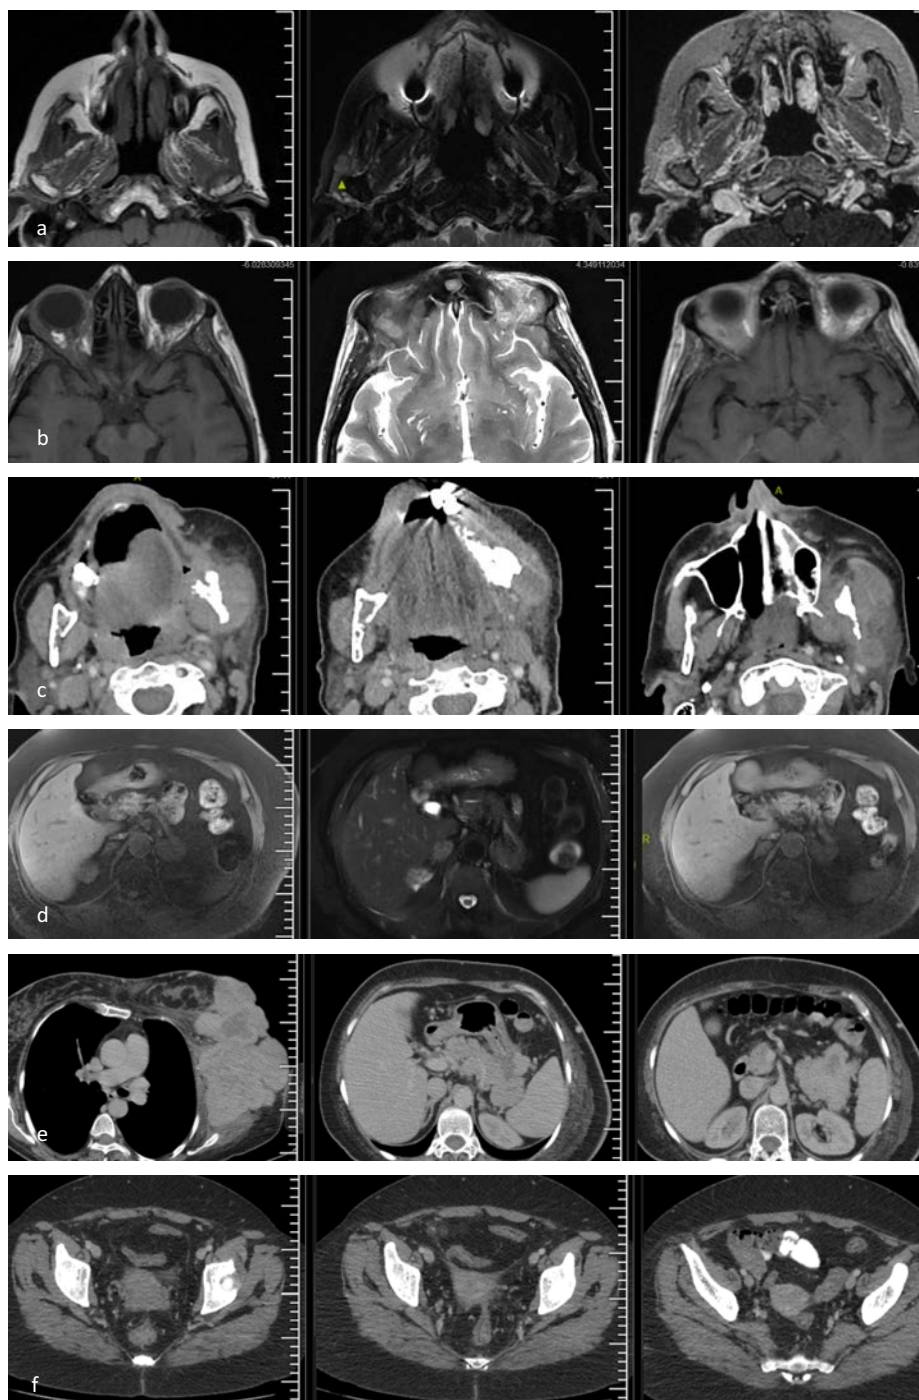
(a) Anterior part of the superficial lobe of the right parotid gland showing hypointense signal on T1-weighted sequences and isointense signal with the parotid gland on T2-weighted sequences, showing peripheral weighted contrast enhancement after IVKM, nodular lesion, (b) A metastatic focus with isointense on T1-weighted sequences and increased intensity on T2-weighted sequences, with mild oedematous sinya extraconal distance and lacrimal gland and upper eyelid level on STIR sequence, extending from the right orbital apex laterally to the retrobulbar area, (c) Left mandibular corpus containing an expansile sclerotic component extending towards the mandibular angulus and causing fractures at the level of the mandibular angulus condyle in places, also metastatic focus with a soft tissue component with a thickness of approximately 10 mm extending into the masseter muscle, (d) Hyperintense in T2A series and hypointense in T1A series in the localisation of the right surrenal lobe body and left surrenal gland body, metastatic lesions with contrast enhancement in early phases, contrast release in late phases and diffusion restriction after IVKM in dynamic series, (e) Metastatic lesion with cystic-necrotic areas approximately 36×24 mm in the tail of the pancreas with unclear borders and (f) Both ovaries contain heteogenous hypodense masses with increased size.
